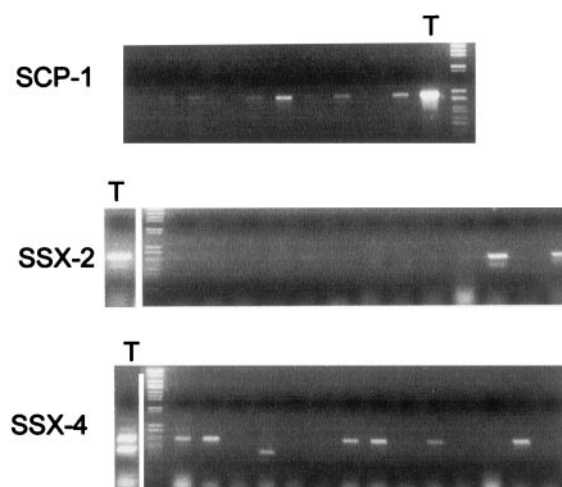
RT-PCR for the expression of the CT genes SCP-1, SSX-2, and SSX-4 in human brain tumors. An equal amount of testis RNA was used as a representative positive control. *Top*, expression of SCP-1 by (from left to right with case numbers as indicated in Tables 1 and 3) astrocytoma II (case 12 of Table 1), astrocytoma IV (case 20, Table 1), oligodendroglioma (case 3, Table 1), oligoastrocytoma (case 10, Table 1), oligoastrocytoma (case 11, Table 1), astrocytoma IV (case 34, Table 1), meningioma (case 1, Table 3), astrocytoma IV (case 26, Table 1), astrocytoma IV (case 18, Table 1), astrocytoma IV (case 31, Table 1), and testis (T) markers. *Middle*, expression of SSX-2 by testis (T) markers, oligoastrocytoma (case 10, Table 1), oligodendroglioma (case 5, Table 1), astrocytoma IV (case 20, Table 1), oligodendroglioma (case 3, Table 1), astrocytoma II (case 12, Table 1), astrocytoma IV (case 33, Table 1), oligoastrocytoma (case 8, Table 1), oligodendroglioma (case 6, Table 1), astrocytoma IV (case 19, Table 1), meningioma (case 1, Table 3), oligoastrocytoma (case 11, Table 1), anaplastic meningioma (case 6, Table 3), and oligoastrocytoma (case 11, Table 1). *Bottom*, expression of SSX-4 by testis (T) markers, astrocytoma IV (case 29, Table 1), astrocytoma II (case 16, Table 3), oligodendroglioma (case 7, Table 1), oligodendroglioma (case 5, Table 1), astrocytoma IV (case 18, Table 1), oligodendroglioma (case 3, Table 1), astrocytoma IV (case 33, Table 1), oligoastrocytoma (case 8, Table 1), astrocytoma II (case 15, Table 1), astrocytoma II (case 13, Table 1), astrocytoma IV (case 22, Table 1), meningioma (case 1, Table 3), oligoastrocytoma (case 11, Table 1), and anaplastic meningioma (case 6, Table 3).
